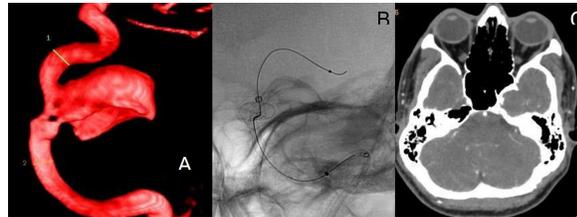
(A) Cavernous part of internal carotid artery showing saccular aneurysm with parent artery fenestration; (B) post procedure CT showing the position of flow diverter; and (C) follow-up CT showing thrombosed aneurysm and patient stent.
